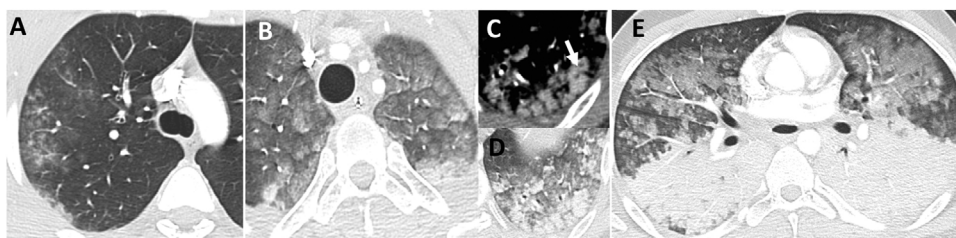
Chest CT images of three different blunt trauma patients with different lung contusion patterns. A) Axial image (lung window) showing centrilobular nodules ('tree-in-bud' sign). B-D) Axial image (B, lung window) showing ground-glass opacities and axial images (C, mediastinal window and D, lung window) showing some high-density opacities in the mediastinal window (arrow), with unaffected interlobular septa. E) Axial image (lung window) showing ground-glass opacities and consolidations. When the bronchi are not filled with blood, air bronchograms can be seen within the pulmonary contusions.
